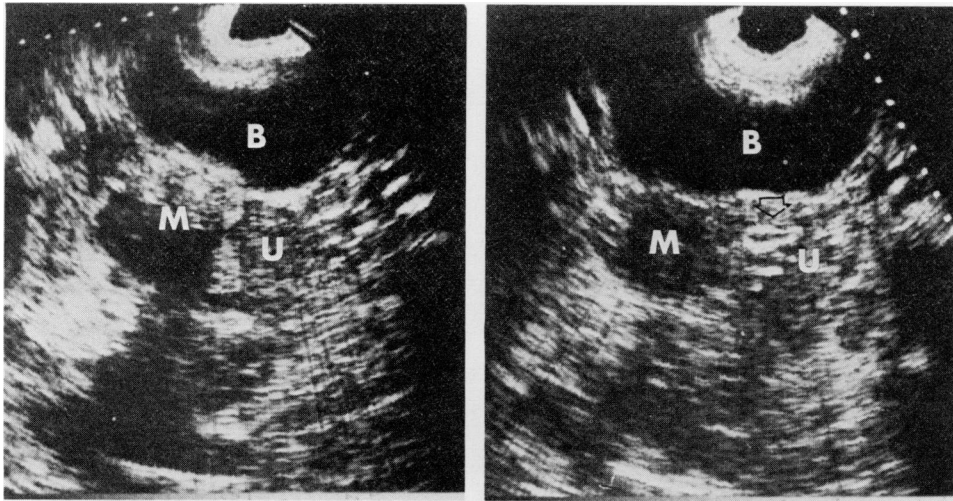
Ultrasound of the pelvis shows the bladder (B), the uterus (U), the IUD (*open arrow*), and a right complex pelvic mass (M).
